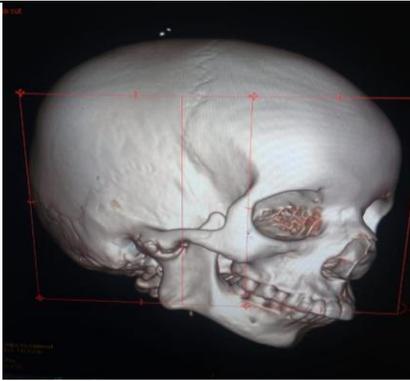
CT scan showing ankylotic mass with high coronoid growth (Right)
